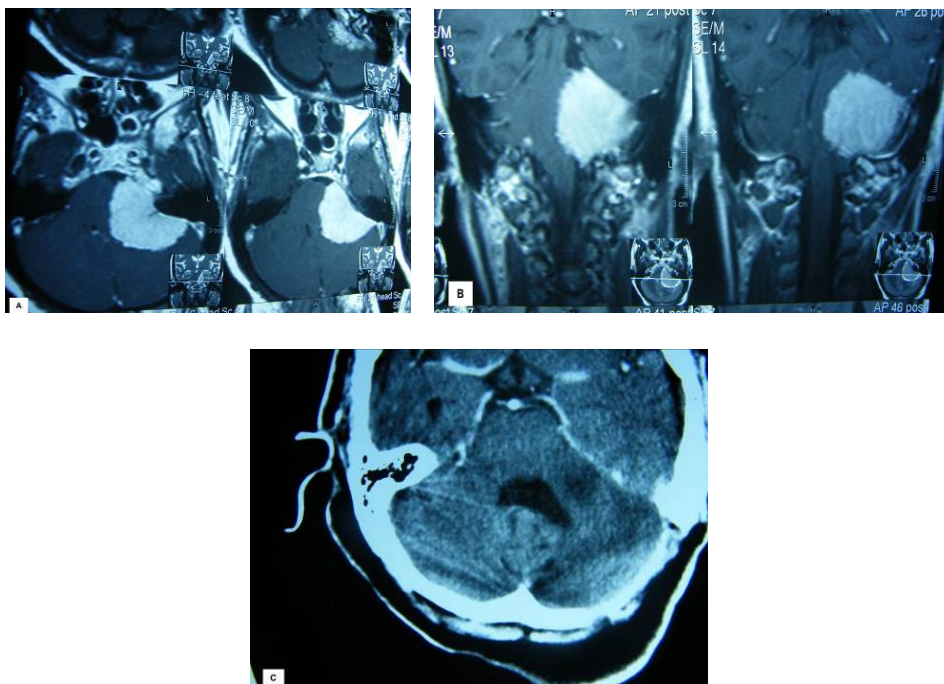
Axial (A) and coronal (B) T1 MR images showing a tumour with an extensive base located at the posterior surface of the petrous bone. (C) Follow up contrast enhanced CT scan of the same case.
